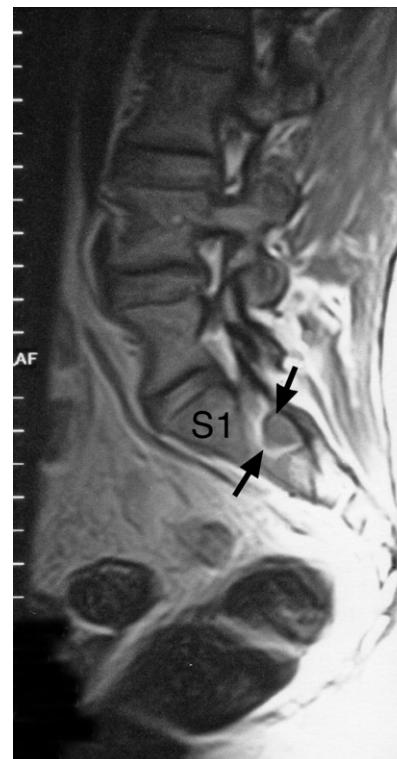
Lumbosacral MRI parasagittal image showing a Tarlov cyst (black arrows) at the S1–2 level.
